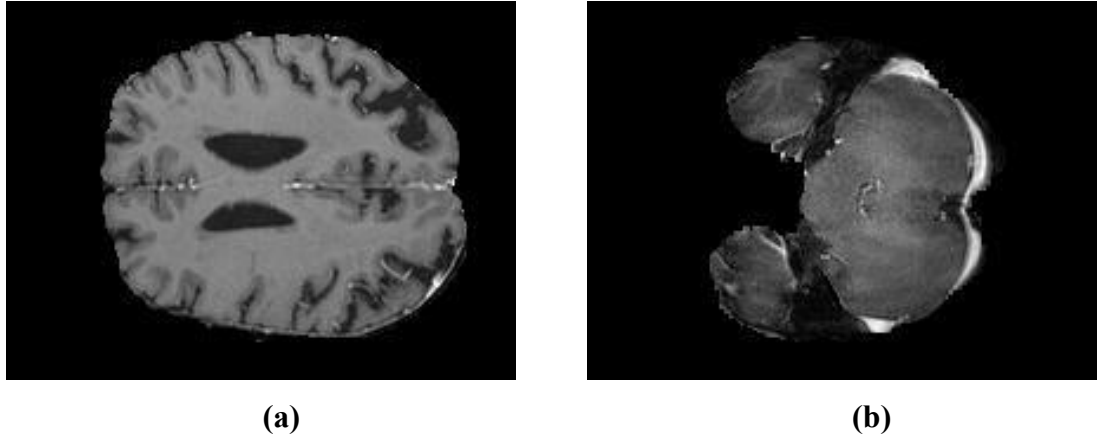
Normal MRI slices from challenge MICCAI (BRATS2012-BRATS-1) dataset, (a) Slice 119 of patient BRATS_HG0010, and (b) Slice 54 of patient BRATS_HG0008
